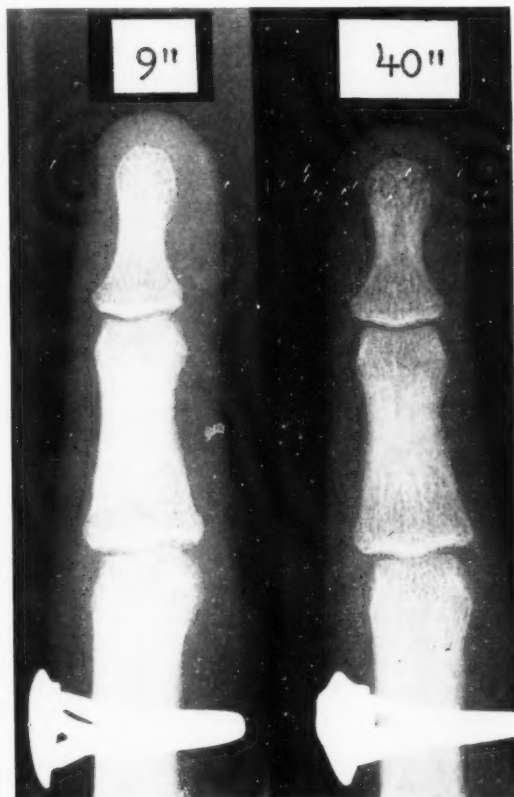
Demonstration of the effect of a short object-film distance in relation to focal-film distance. Radiographs of a finger taken at 9" and 40" respectively show the same detail to the unaided eye.
